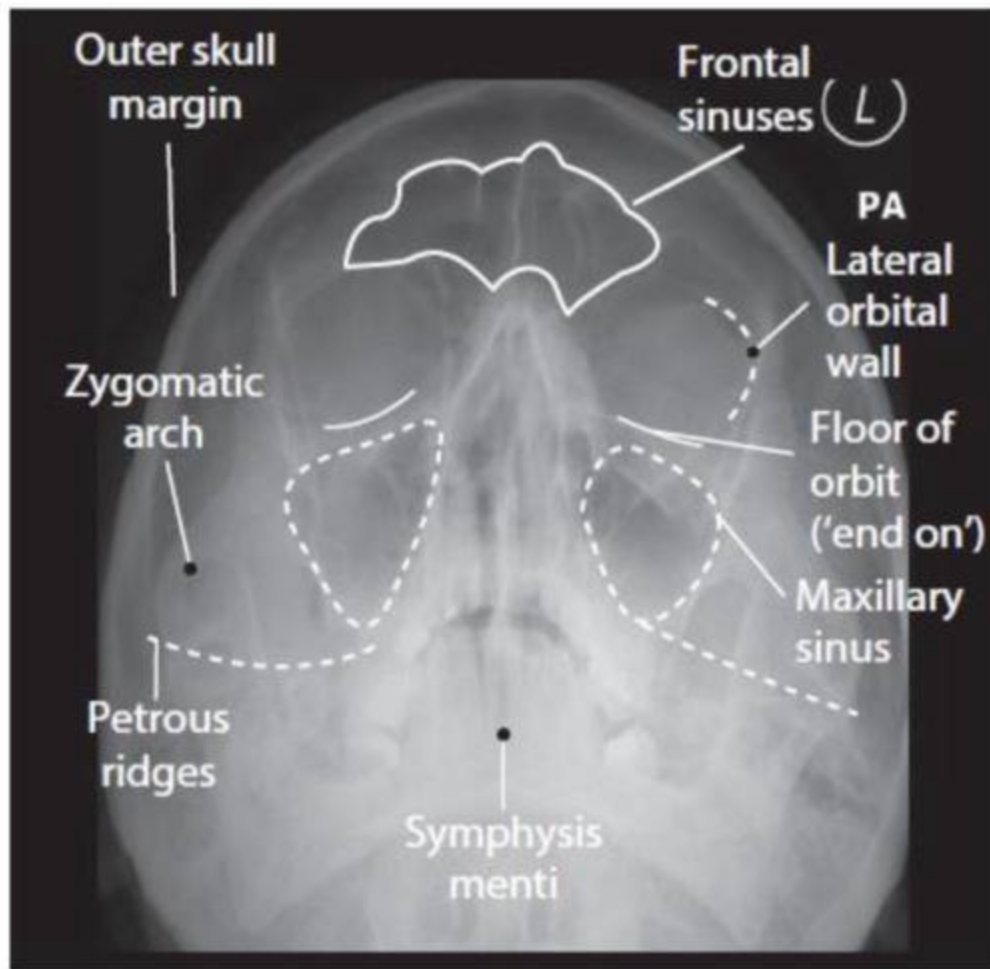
Labelled radiograph showing important structures.
